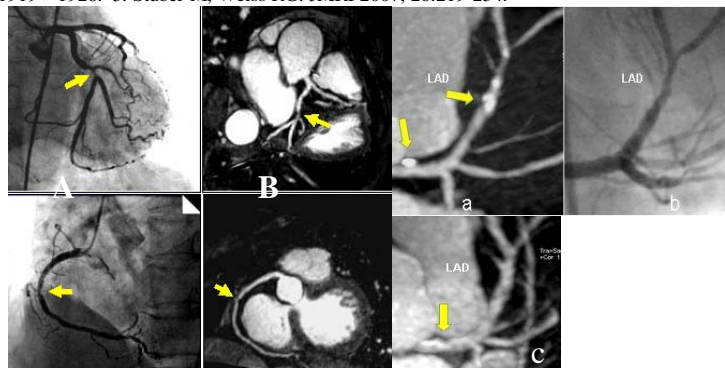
A 75-year-old patient. Significant stenosis at proximal LCX and middle RCA (arrow). Consistent finding with CAG (A) and coronary MRA (B). Fig. 2 A 70-year-old patient. Representative CTA (a), CAG (b) and MRA (c) of the left coronary artery from a patient with diffused calcified plaque.
